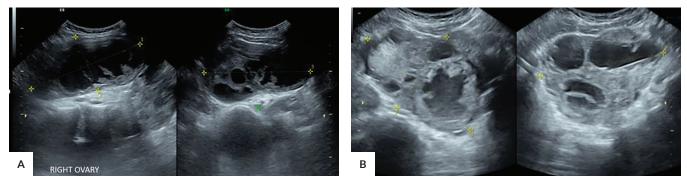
Pelvic ultrasound (US). Sagittal and transverse images of the right adnexa (A) showed an enlarged right ovary which measures 12.6 x 11.8 x 6.6 cm, (L x H x W) with multiloculated solid mass lesions containing locules of varying sizes with solid components with rich color flow (IOTA Adnex, risk of malignancy = 65.2%, chance of benign tumor = 34.8%, risk of borderline tumor = 15.0%.). (B) The left adnexa also showed solid multiloculated mass lesions measuring 11.7 x 10.7 x 7.4 cm, (L x H x W) containing locules of varying sizes with solid components with rich color flow (IOTA Adnex, risk of borderline tumor = 20.4%).
